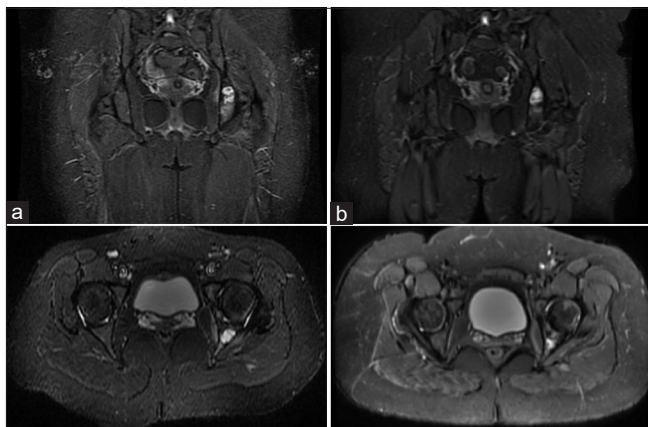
1.5 T and 3.0 T magnetic resonance imaging (MRI) of coronal and axial (STIR) sections of posterior column of the left posterior acetabulum post-radiofrequency ablation (RFA) treatment showing no lesional progression. (a) 1.5 T MRI of coronal and axial (STIR) sections of early post-operative RFA period (1 month) showing some perioperative edema and residual size of the lesion. (b) 3.0 T MRI of coronal and axial (STIR) sections of late post-RFA period (32 months) showing resolution of early perilesional edema and absence of progression of the size of the lesion.
